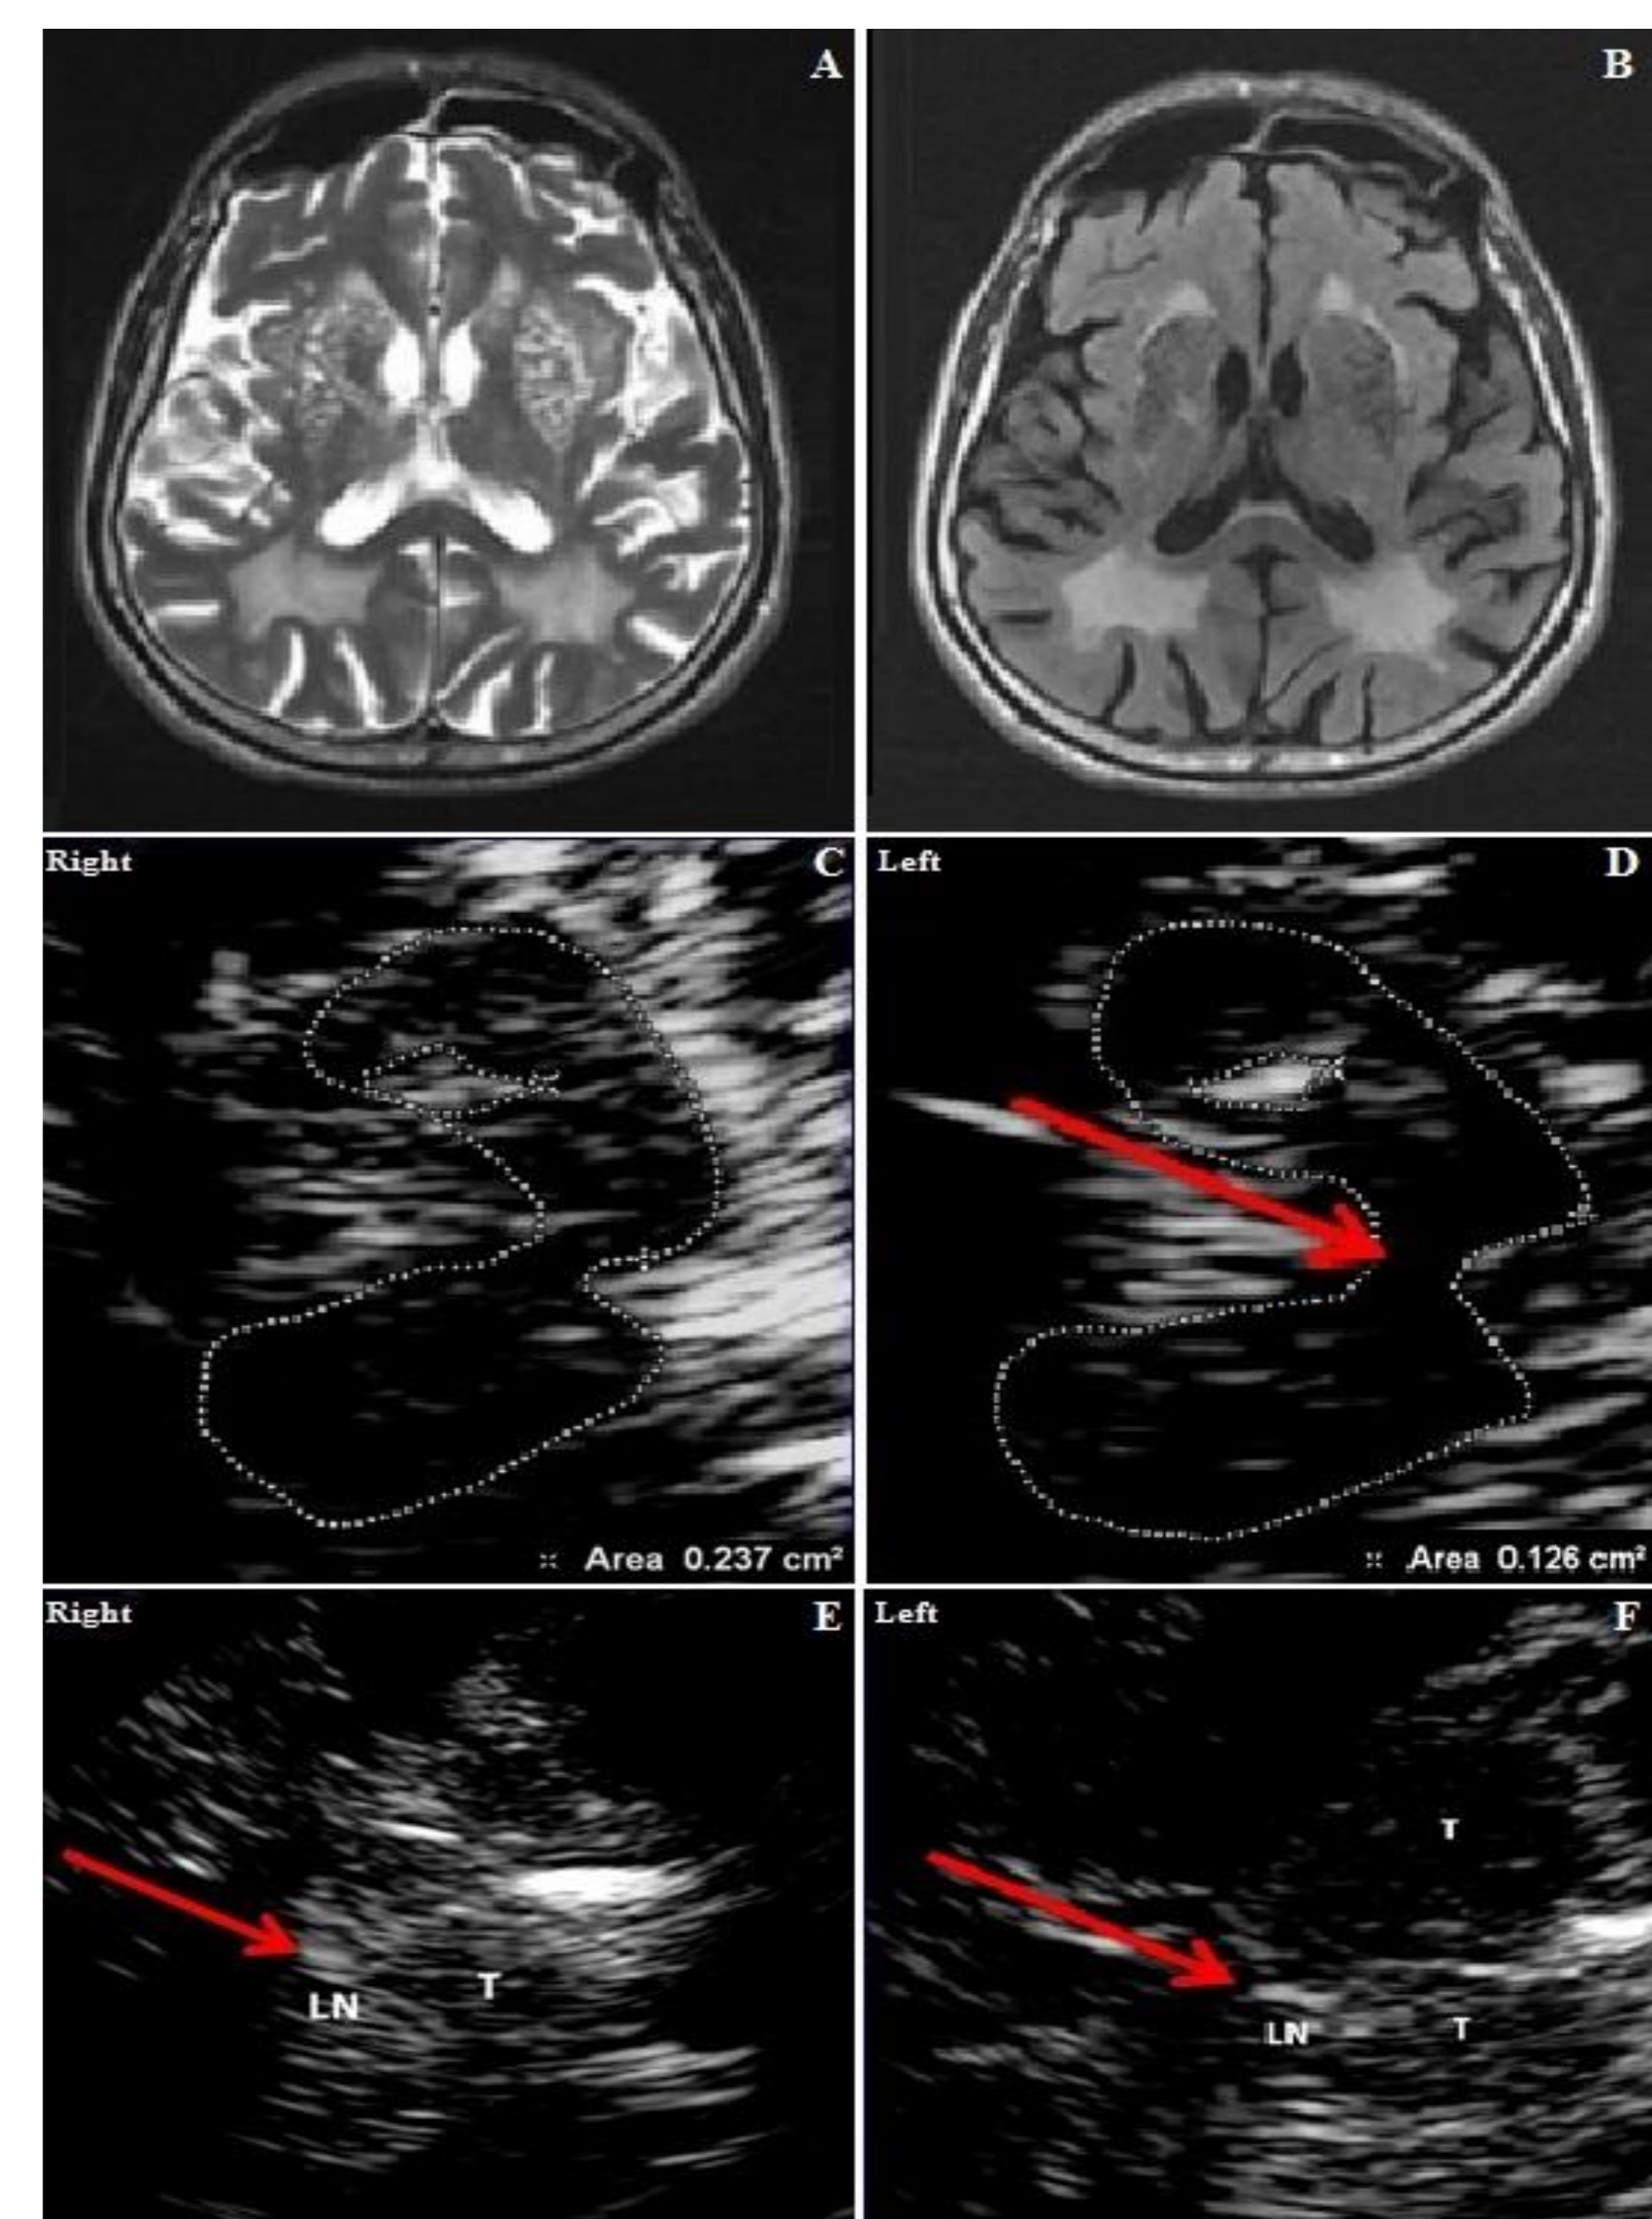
Neuroimaging and transcranial sonographic study in twin B. A-B: FLAIR and T2-weighted brain MRI images show a pattern of lesions distribution similar to that of twin A: typical white matter changes of CADASIL, lacunar infarction involving the right anterior limb of internal capsule and cribriform state of putamen, pallidum and caudate nuclei. C-D: Through a transtemporal bilateral approach, TCS images show enlarged right substantia nigra hyperechogenicity (0.237 cm²) and left substantia nigra hyperechogenicity within normal range with interruption of the midline raphe (red arrow). E-F: Through a transtemporal bilateral approach, TCS images show bilateral hyperechogenicity of lenticular nucleus (LN - red arrows) and slight increase of the 3° Ventricle width (T: Thalamus).
